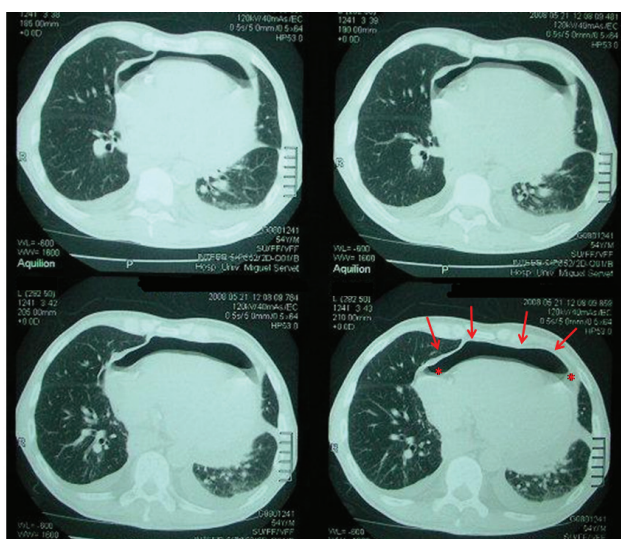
Chest computed tomography scan. Note the presence of air (arrows) in the most anterior part of the pericardial sac (with the patient in the supine position) associated to small amount of pericardial fluid (asterisks), bilateral pleural effusion and parenchymal opacities in the right superior lobe with signs of infective bronchial compromise.
